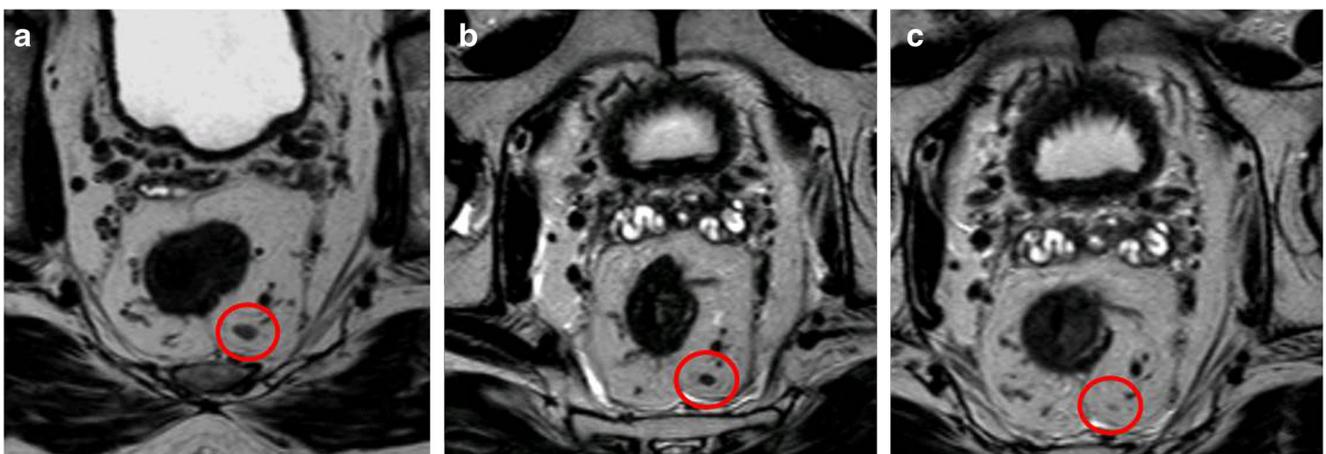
Reactive nodes. A: MRI post-transanal endoscopic microsurgery (TEM). B: MRI 5 months post-TEM. C: MRI 8 months post-TEM. The major difference in post-TEM MRI is that at the first postoperative scan many reactive enlarged nodes are found which can confuse the radiologist
